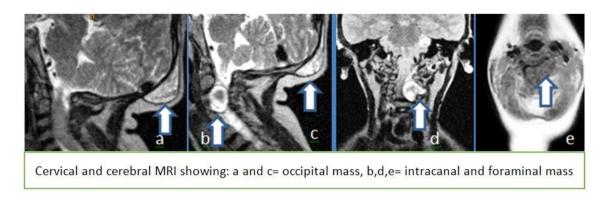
Craniocervical Magnetic resonance image (MRI) showing an intra canal mass opposite C4 with spinal cord compression
